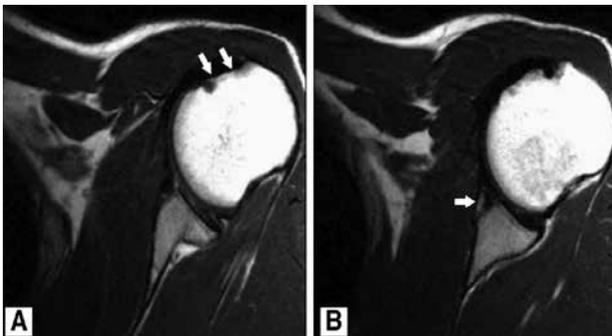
Magnetic resonance images showing Hill-Sachs (A) and, Bankart lesions (B)
